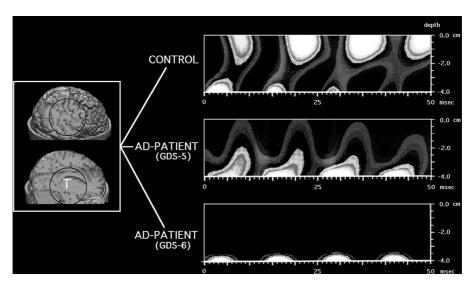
Magnetic field tomography (MFT) images of steady-state gamma-band activity from a normal elderly adult and two agematched patients with Alzheimer dementia (AD; moderate AD: Global Deterioration Scale (Reisberg et al., 1982) GDS-5, and severe AD: GDS-6) within the thalamo-cortical system. The location of the cylindrical source space is outlined on the 3D reconstructed MRI scan (left). The top face of the cylinder is close to the temporal area around the auditory cortex, while the bottom face is close to the thalamus (T). The axis of the cylinder is the midpoint of the MEG-probe placement. The MFT images are shown at 1 ms steps within a time window of 50 ms. The onset of activity at the thalamic level precedes the onset of activity at the cortical level by \approx 3 ms. Note the altered gamma-band activation in AD patients, especially at cortical level.
